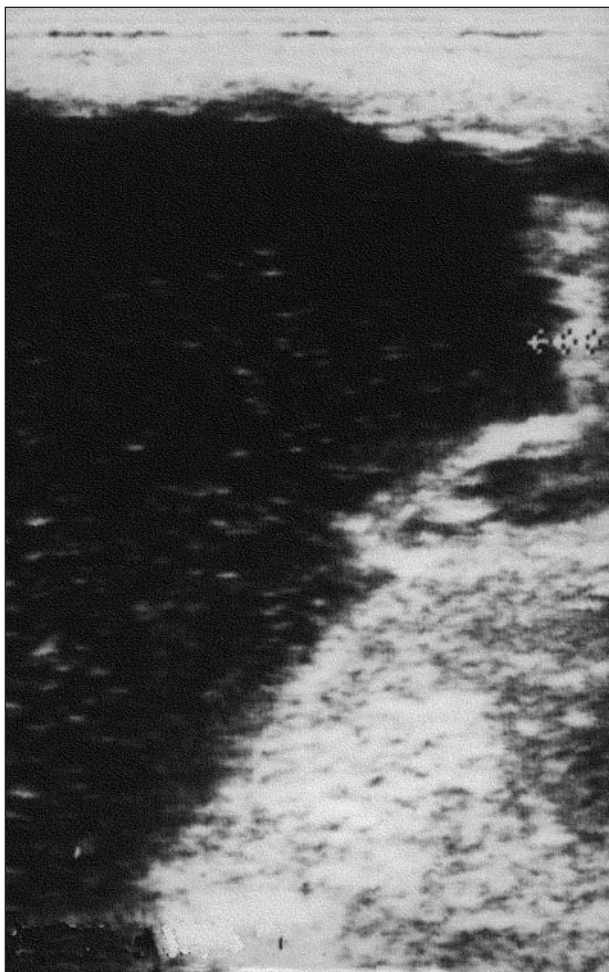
Ultrasonographic image of allantoic fluids in a pregnant mare on day 71 of gestation. Allantoic fluid score is 3.
